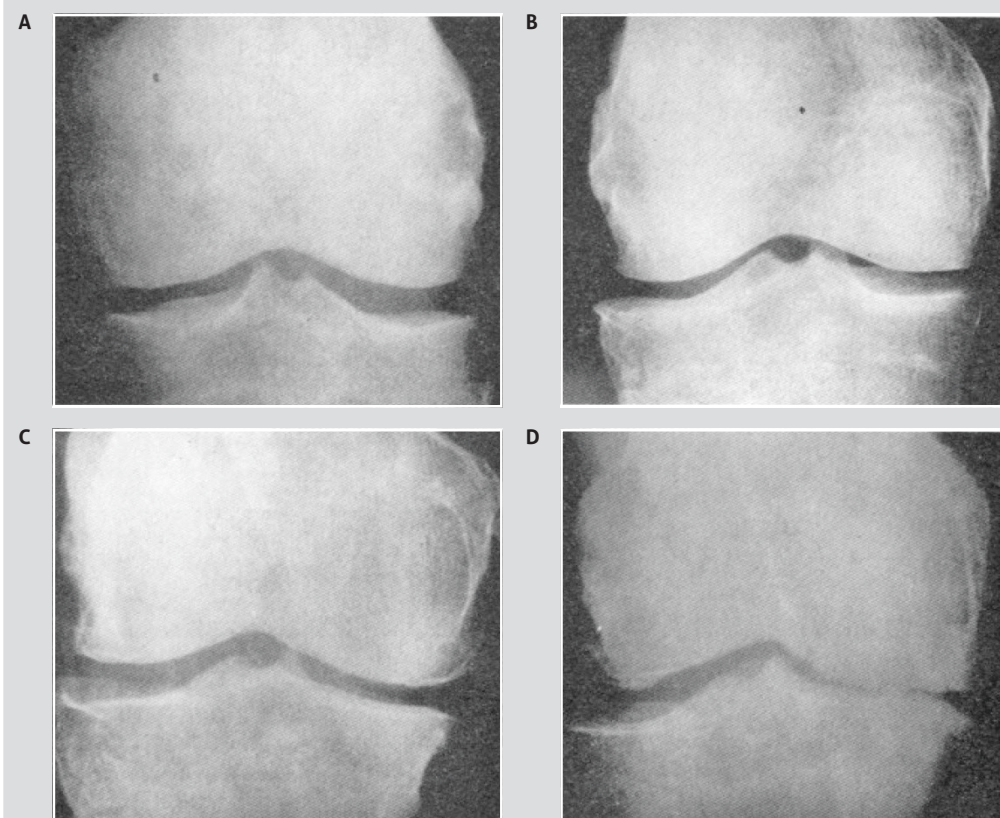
Radiographic classification of osteoarthritis.
